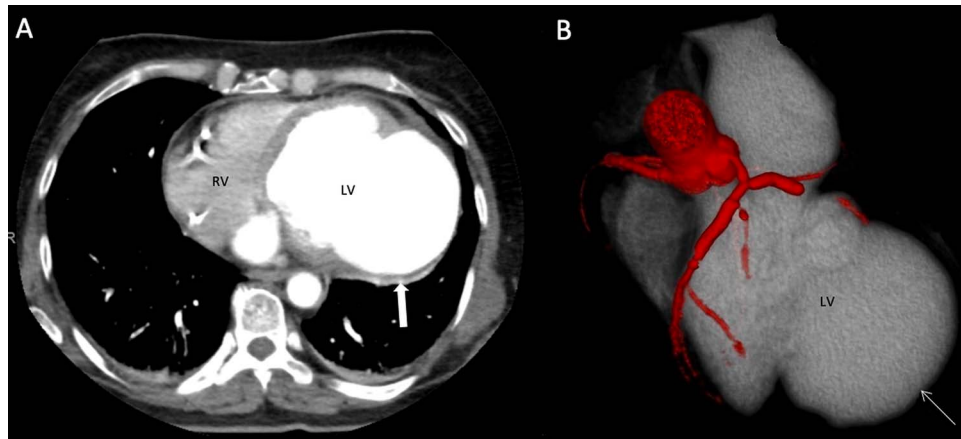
Axial CT (A) showing large aneurysm and rim of hematoma (bold-arrow), CT reconstruction images (B) showing size of aneurysm (arrow).
